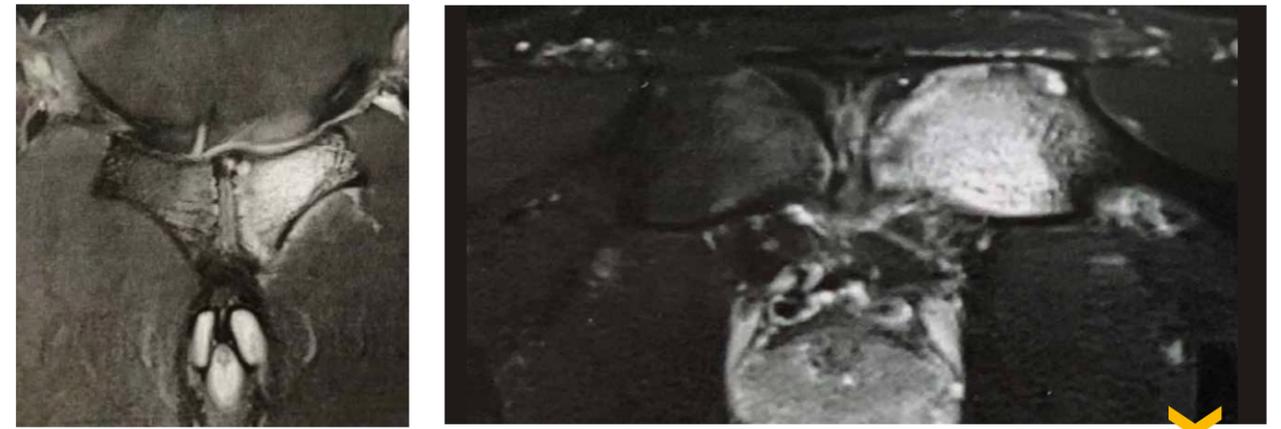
A+B MRI on 31.07.2018 after seven weeks' break from training, still with massive pain
